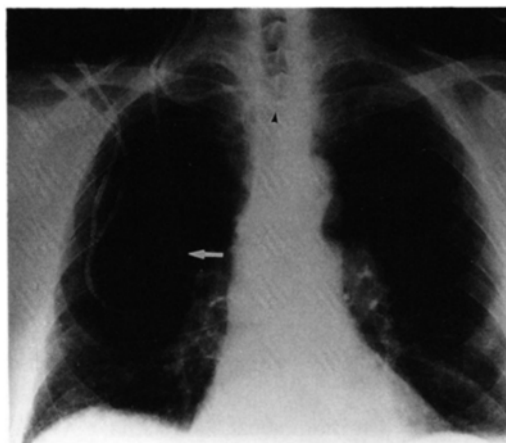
Chest X-ray following catheter placement shows the catheter tip (arrow head) in the region of the left brachiocephalic vein. The exit site of the catheter from the subcutaneous tunnel is indicated (white arrow).
